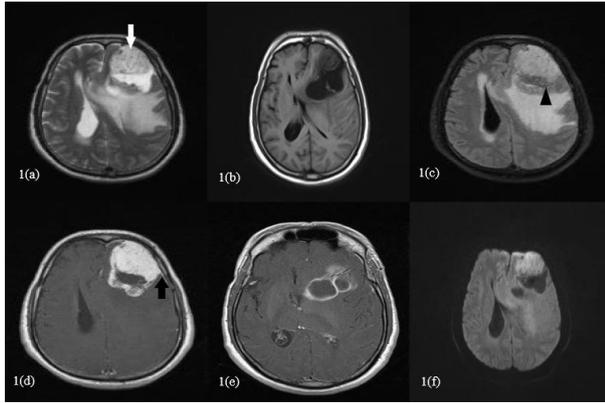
1(a) T2 shows a hyperintense lesion with flow void signals of vessels inside the solid component (white arrow); 1(b) T1 shows iso to hypointense lesion; 1(c) FLAIR shows CSF cleft sign (black arrowhead) and significant perilesional oedema; 1(d) T1 Contrast shows homogenous solid component enhancement with Dural Tail sign (black arrow); 1(e) T1 contrast shows cystic peripheral enhancement; 1(f) Diffusion shows mild restriction.
